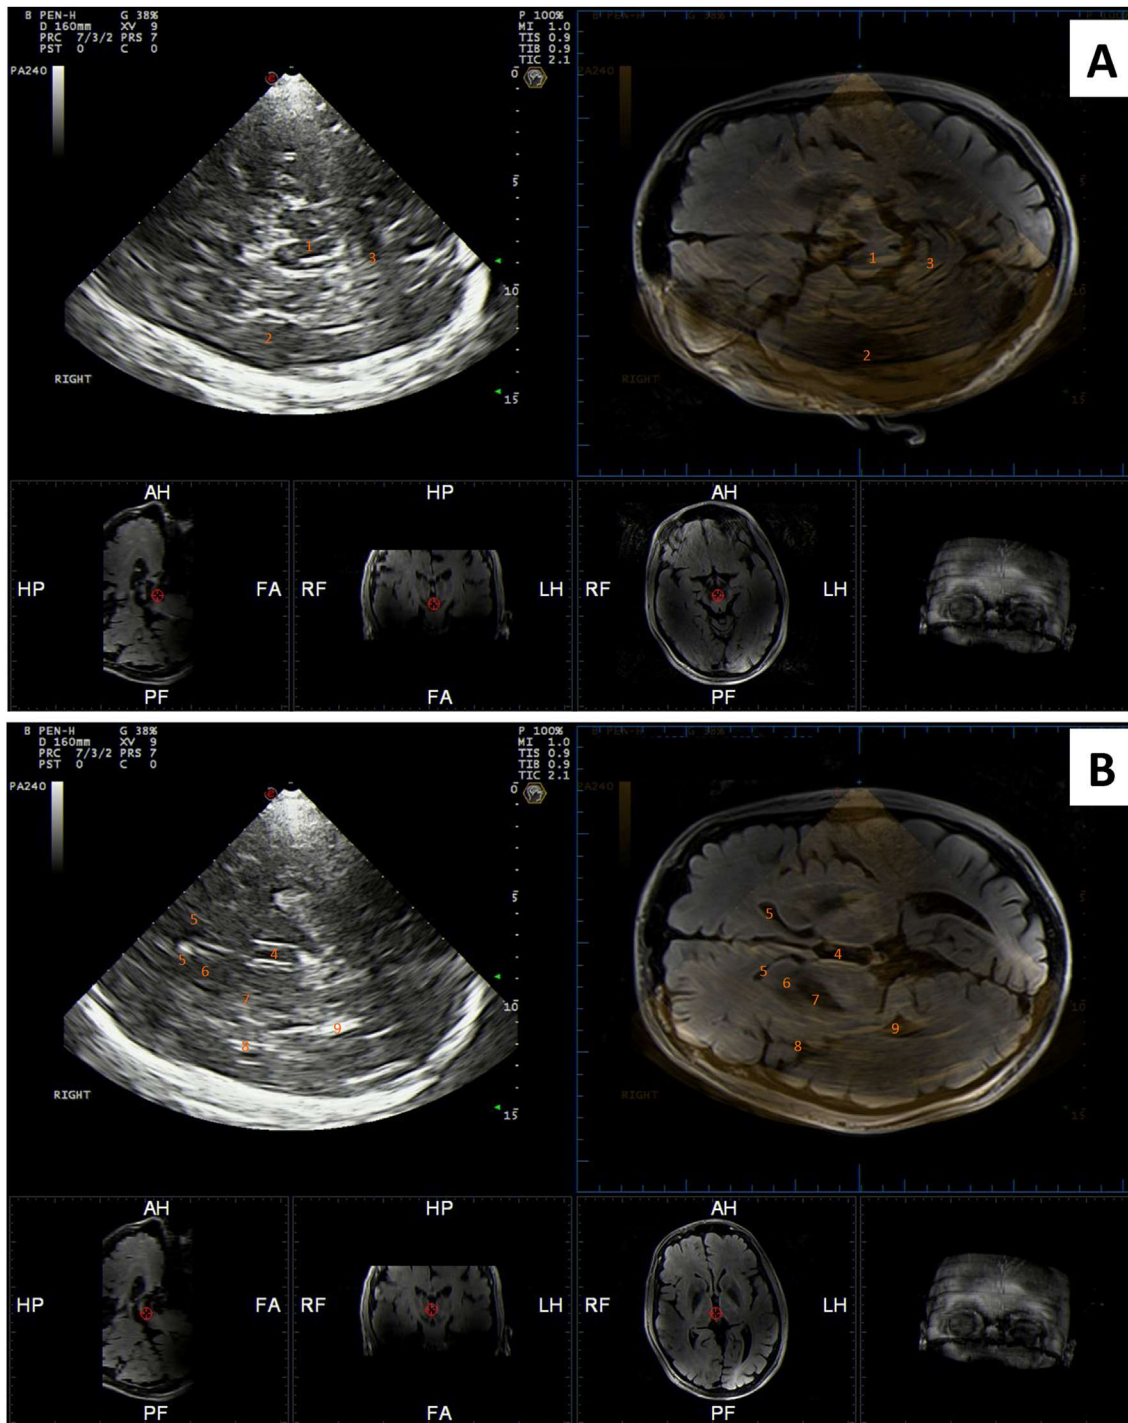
Typical TCS findings in WD patient with corresponding MRI images using the fusion imaging technique. A) axial mesencephalic plane showing normal echogenicity of a substantia nigra; B) axial thalamic plane showing hyperechogenic lentiform nucleus. Numbers indicate following anatomical structures: 1 – mesencephalon; 2 – temporal lobe; 3 – cerebellum; 4 – third ventricle; 5 – frontal horn of lateral ventricle; 6 – caudate nucleus; 7 – lentiform nucleus; 8 – insula; 9 – occipital horn of lateral ventricle.
